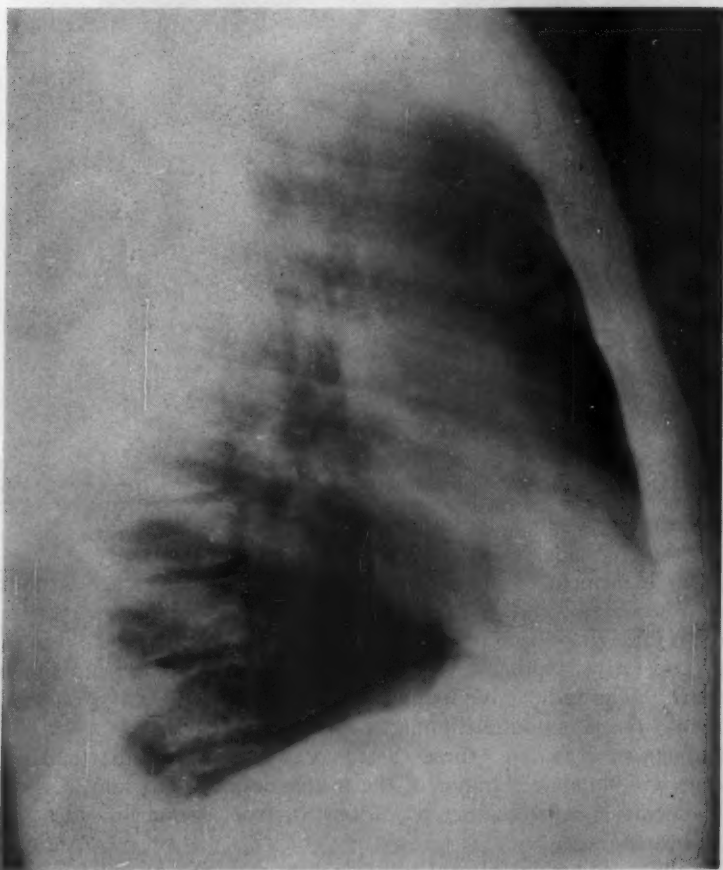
The right lateral x-ray examination showed the density to be round and to overlie the cardiac shadow. Because the lesion was indeterminate, a thoracotomy was performed and the mass removed. It was a "spring water" type of cyst, and proved to be a pericardial cyst. This is a characteristic history and radiographic appearance for a pericardial cyst. Most are located in the right cardiophrenic area.
